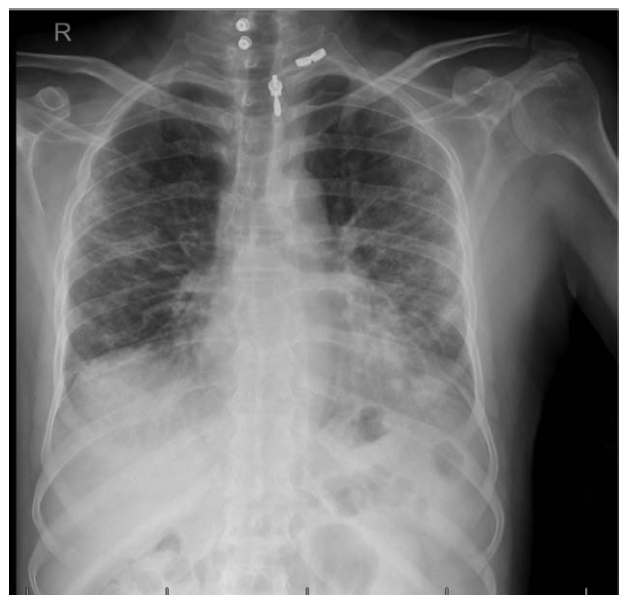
X-ray chest antero-posterior view: showed signs of resolved pneumonia.
